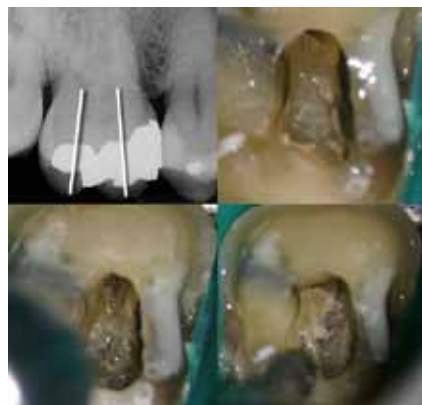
Dystrophic calcification confounds even the most experienced clinician. The key to identification of the orifices is to regress the inner space using the continuum, cusp tip, pulp horn and canal orifice. In lieu of an ultrasonic tip, which tends to chop the stone and scatter debris, gross removal is best done with a diamond bur in a high-speed handpiece. The fine removal of residue can be done with a multi-fluted carbide bur to trace the fusion lines.
